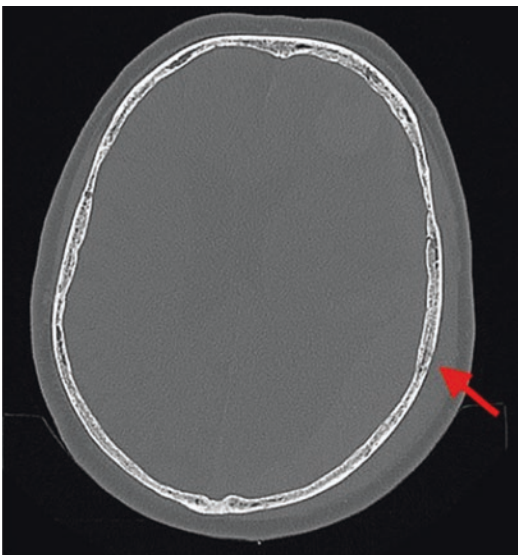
Comparison of axial CT of the head with bone reformats and 3D reconstructions demonstrating a subtle left parietal bone fracture that is better visualised on 3D reconstructions
